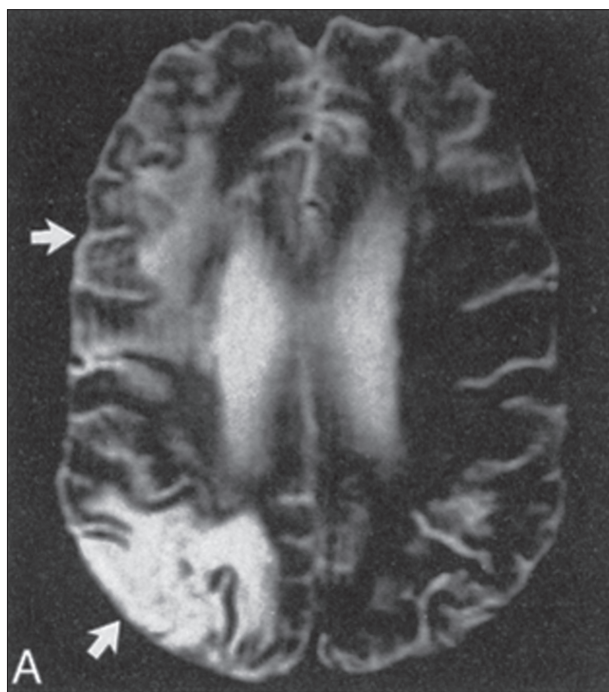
Axial spin-echo MR image of endocranium (3000/90 images) shows T2W/FLAIR hyperintense signal changes (infarcts) in the right cortical gray matter and subcortical white matter (middle cerebral artery distribution, upper arrow; middle cerebral artery/posterior cerebral artery watershed distribution, lower arrow).
